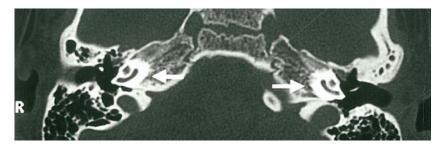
Inner ear CT prior to CI. Arrows indicate an open cochlea on both sides.
